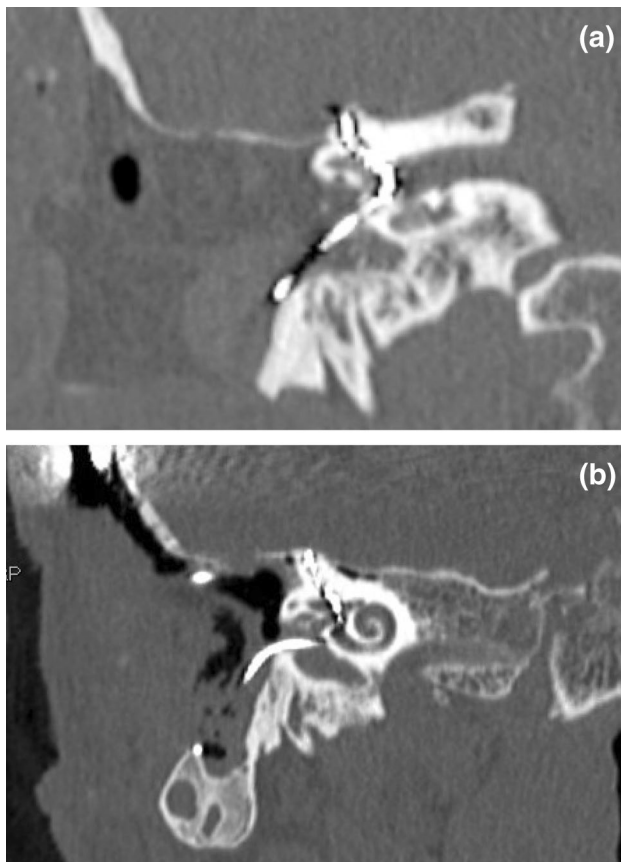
a Coronal CT image of patient with otosclerosis who underwent subtotal petrosectomy for access to round window ossification with electrode array seen in SSC. b Reconstructed CT image of patient with revision implantation with array visible in SSC through vestibule
